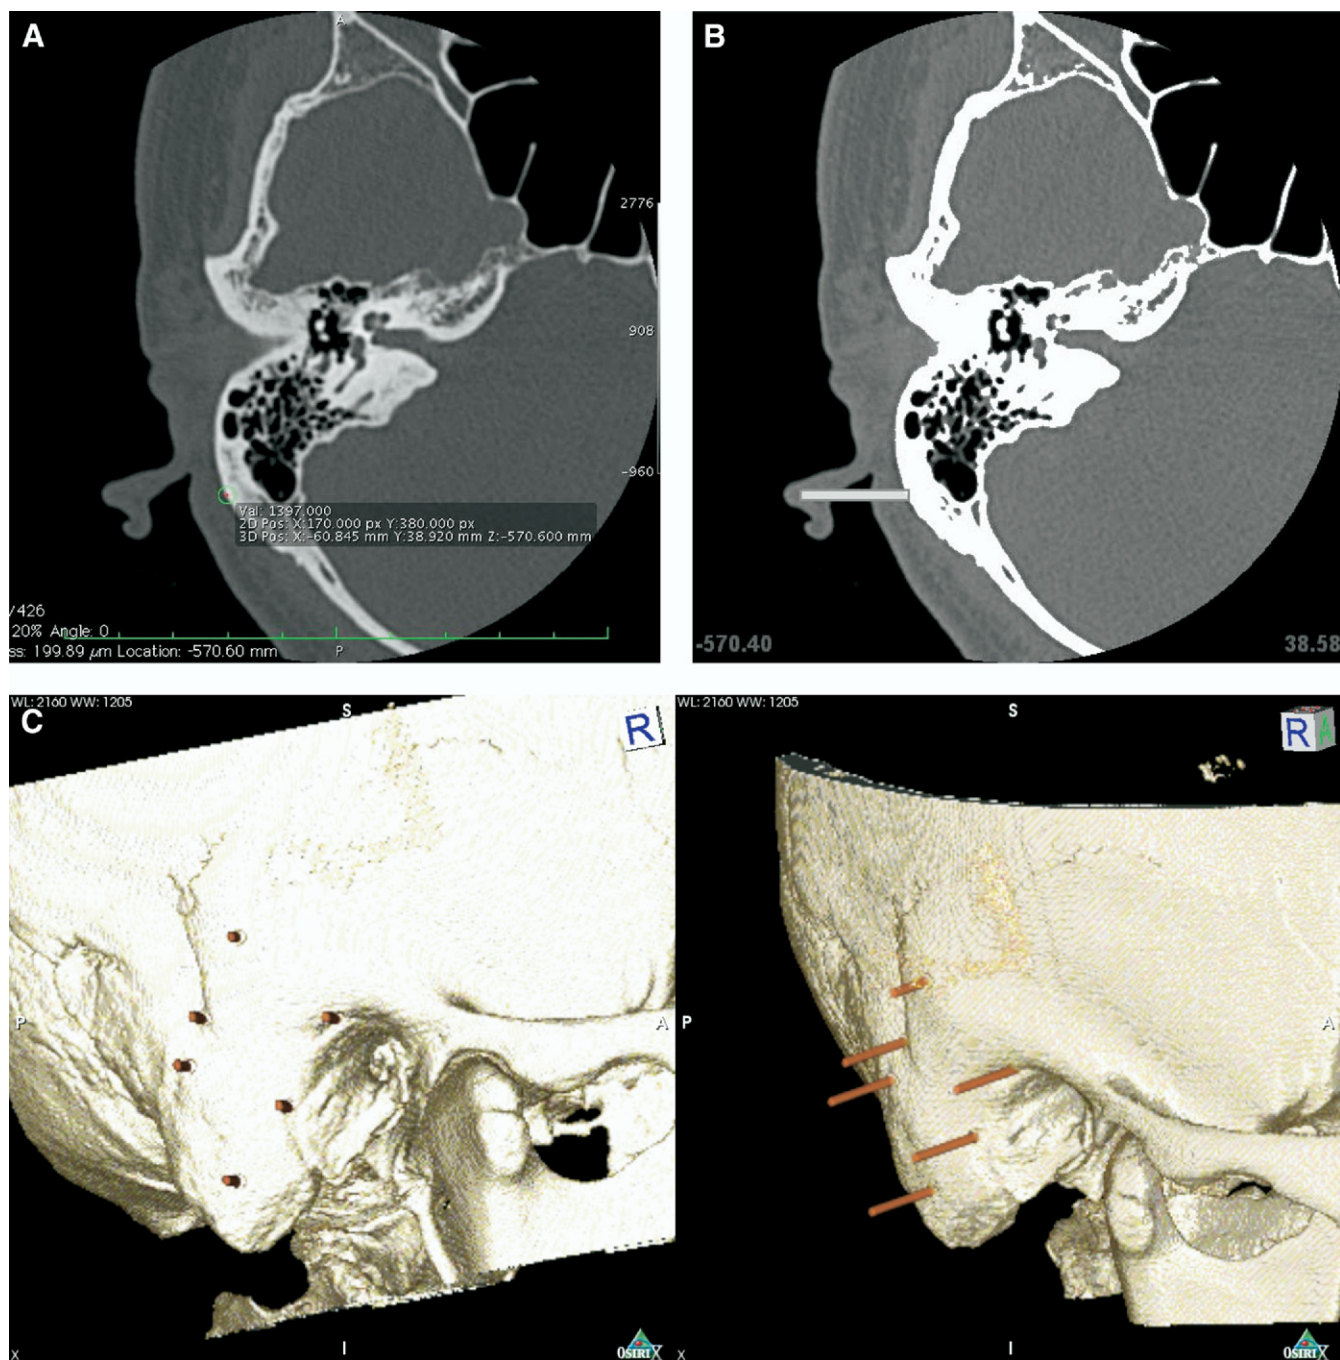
Virtual markers. (A) A CT slice showing one of the virtual markers. (B) The edited CT slice with a cylinder attached on the selected location shown in panel A. (C) 3D volume rendered; edited CT with virtual markers.
